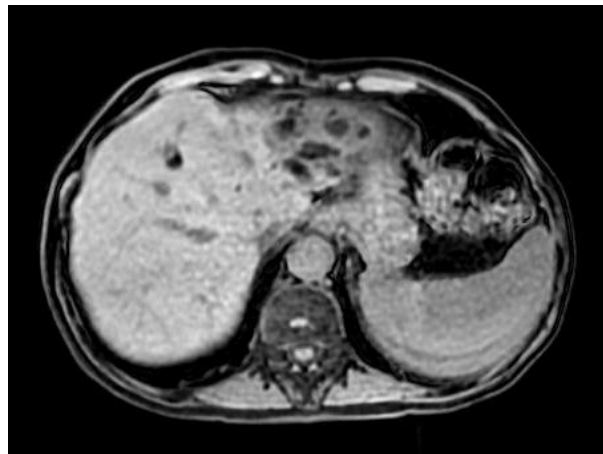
Abdominal MRI: cystic dilatations of the bile ducts in hepatic segments II and III
